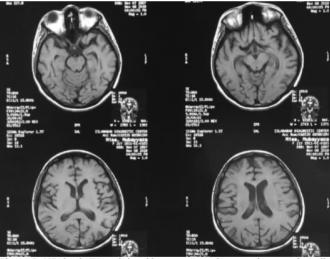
MRI brain T1-weighted images: grossly normal except for mild cortical atrophy.
